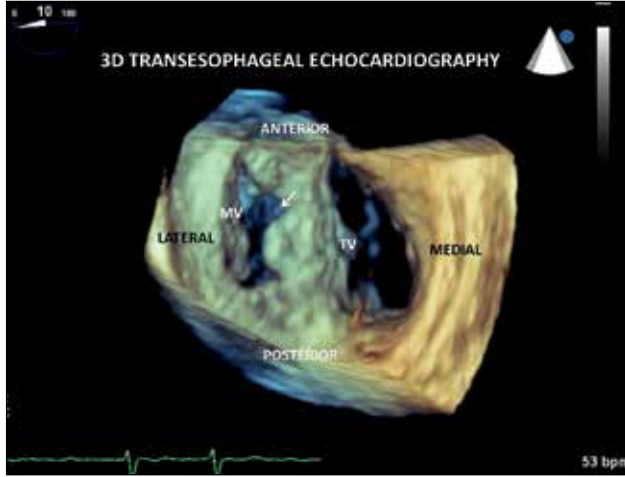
Three-Dimensional transesophageal echocardiographic image viewing from the atria into the ventricles: Displaying lack of interatrial septum, a mitral valve cleft and tricuspid valve
